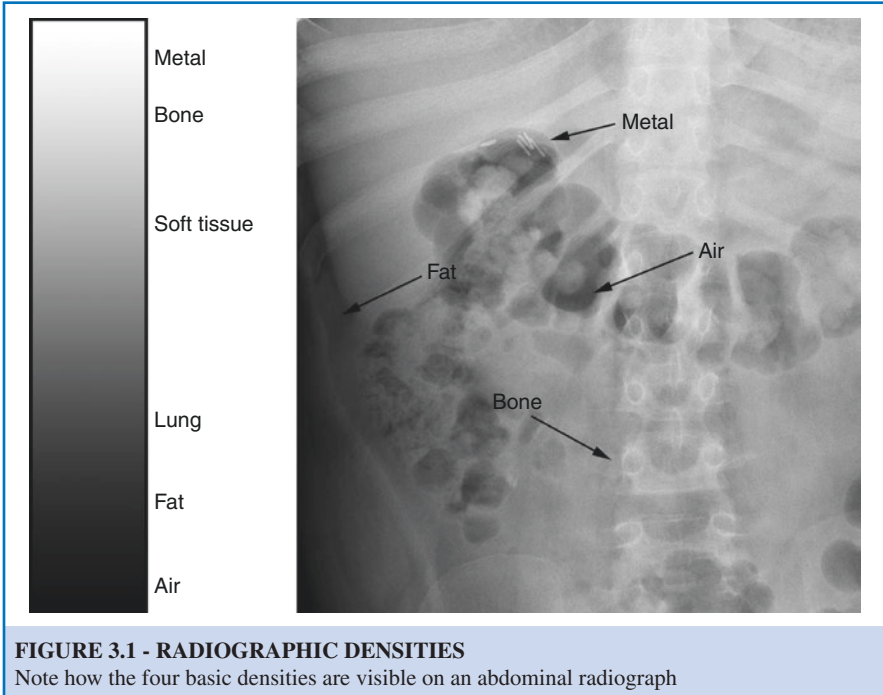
RADIOGRAPHIC DENSITIES
